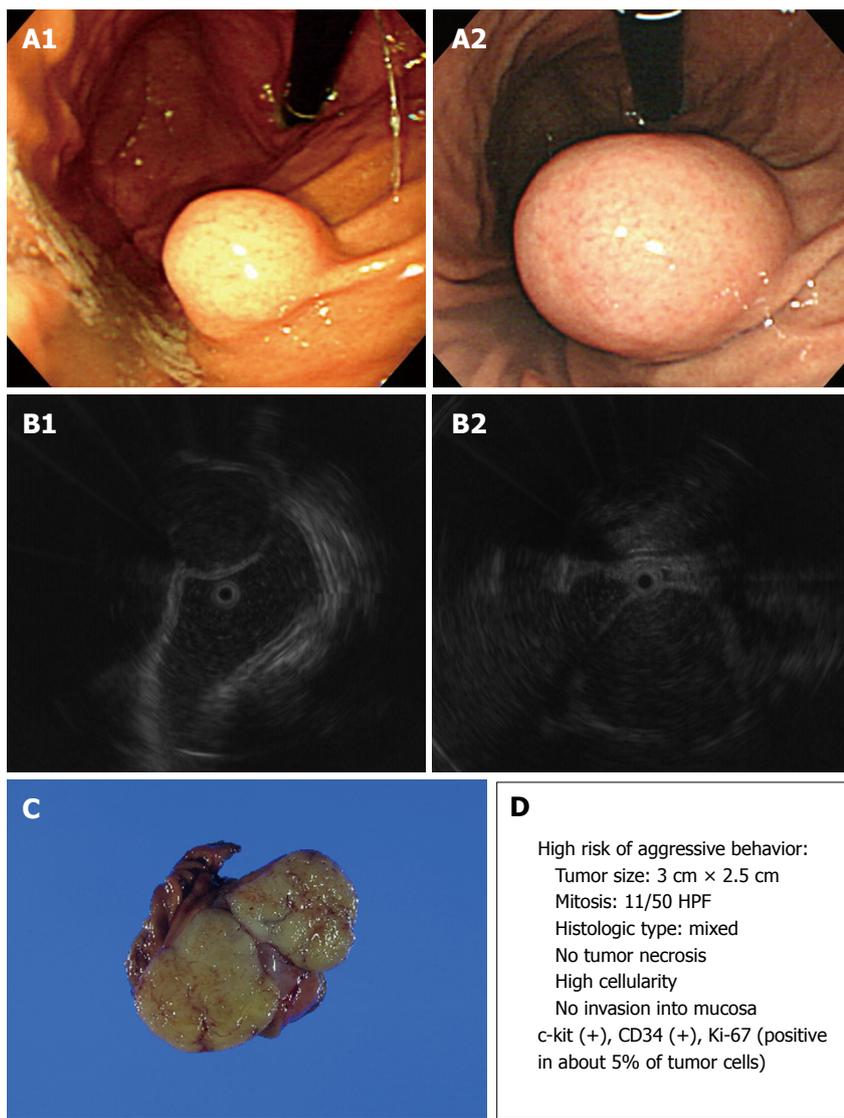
Endoscopic, endoscopic ultrasonography (EUS), and gross findings of gastrointestinal stromal tumors (GISTs). A: Endoscopic view of a round subepithelial mass with a significant interval change; B: EUS shows an ovoid, homogeneous, hypoechoic mass in the fourth gastric wall layer; C: Gross findings of wedge resection reveal a soft, well-defined mass measuring 4.3 cm × 2.7 cm; D: Malignant potential.
